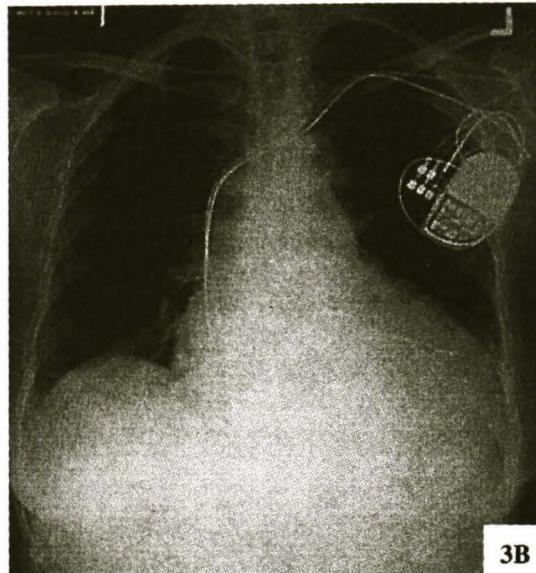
Chest X-ray at implantation.
